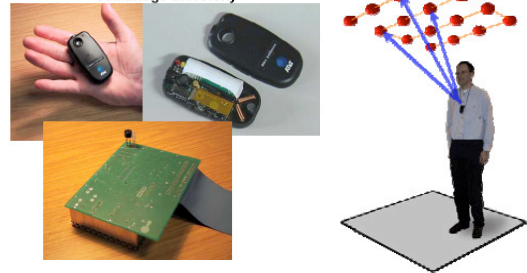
The Active Badge Ultrasonic location mapping system.
